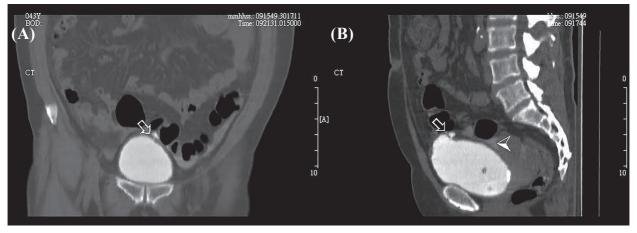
Abdominal computed tomogram cystogram revealed a perforational hole at left upper portion of urinary bladder (arrows), coronal (A), and sagittal sections (B). Contrast medium filled the cul-de-sac space (arrow heads) can be seen.
